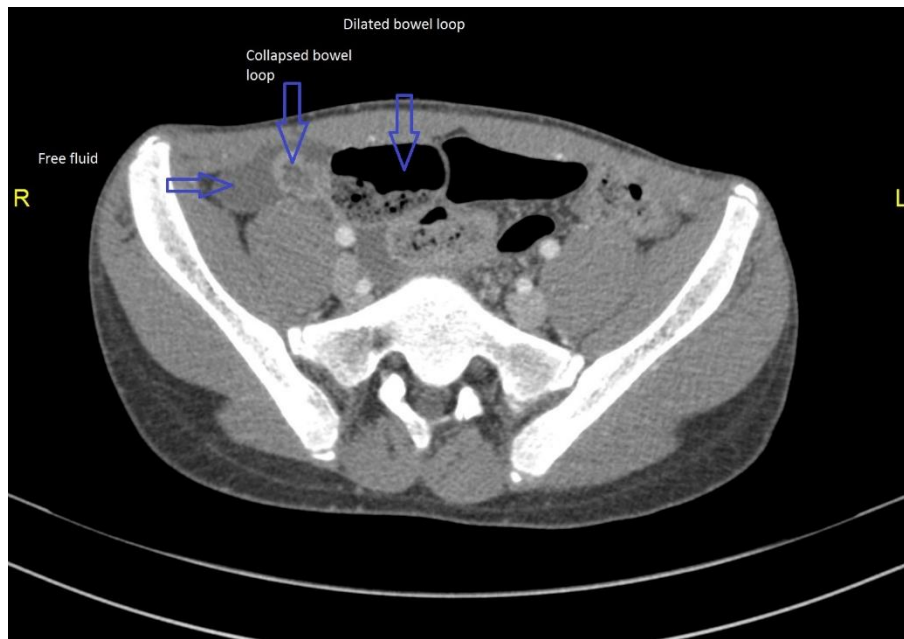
CT scan of abdomen with contrast. Mild free fluid in the abdomen, greatest in the right paracolic gutter and pelvis usual and is likely reactive. Suggestion of bowel obstruction with a point of apparent transition at the right pelvis. The collapsed small bowel suggests wall enhancement and may reflect enteritis. An adhesion is not excluded.
